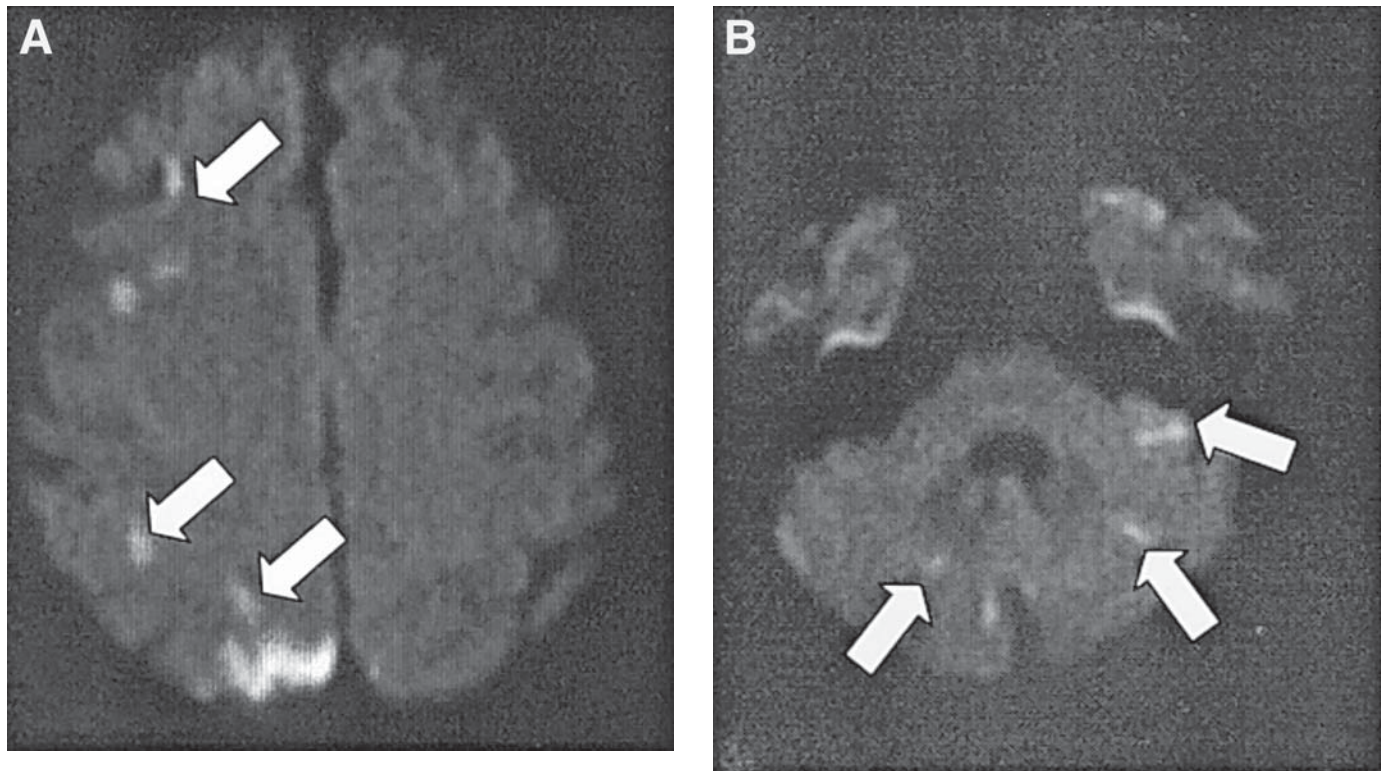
Bronchoscopy procedure-induced tumor emboli. A 70-yr-old woman with nonsmall cell lung adenocarcinoma underwent fiberoptic bronchoscopy and mediastinoscopy with tracheobronchial lymph node biopsy. Two hours after the procedure, she developed left faciobrachial weakness. (A) Diffusion weighted MRI shows right frontal, right parietal, and right occipital infarcts (white arrows). (B) Lower slice from diffusion MR study demonstrates additional acute bilateral cerebellar infarcts (white arrows).
